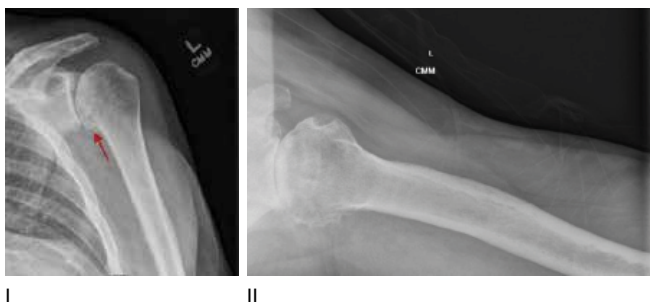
Anteroposterior radiograph of the glenohumeral joint (I) and axillary (II) radiograph of the shoulder demonstrate glenohumeral osteoarthritis with joint space narrowing and inferior spur formation (red arrow) of the humeral head.
